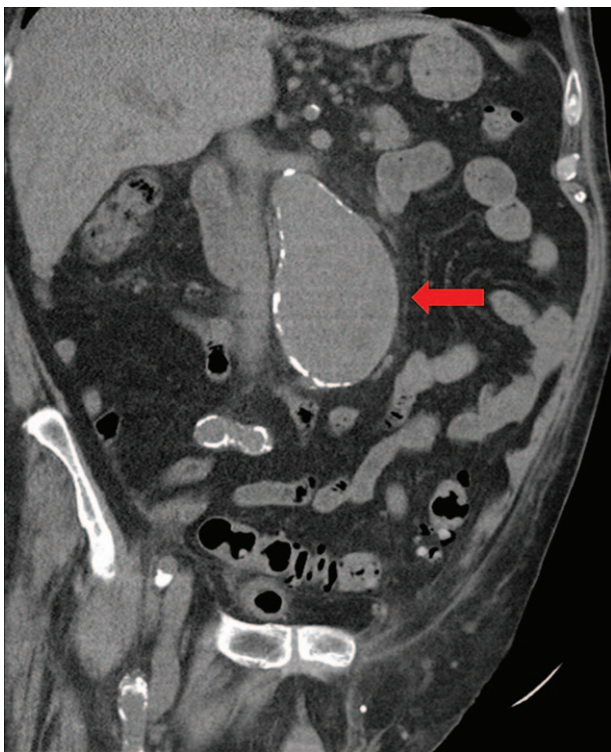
Computed tomography of the abdomen without contrast agent. Arrow points toward the infra-renal aortic aneurysm.
